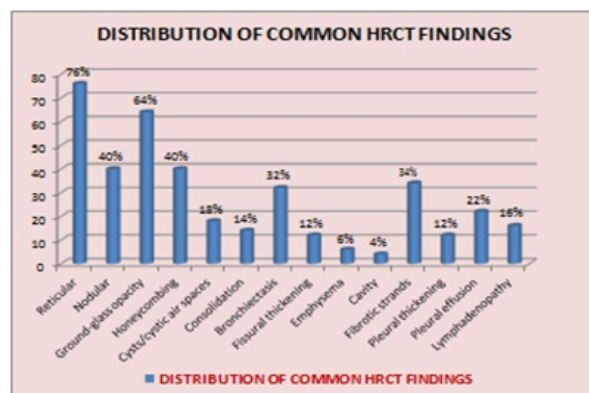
HRCT findings in interstitial lung diseases observed in 50 patients.
